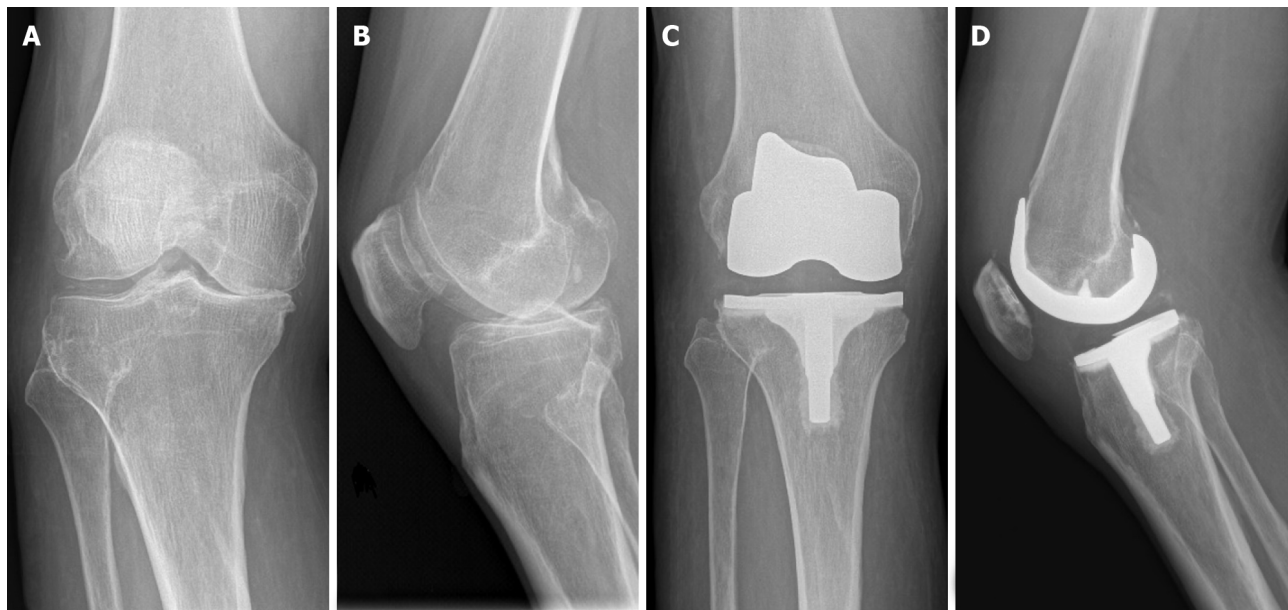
Preoperative anterior-posterior, postoperative anterior-posterior and lateral radiographs. A and B: Preoperative anterior-posterior (AP) and lateral radiographs demonstrating severe primary osteoarthritis; C and D: Postoperative AP and lateral radiographs demonstrating cruciate retaining total knee arthroplasty.
